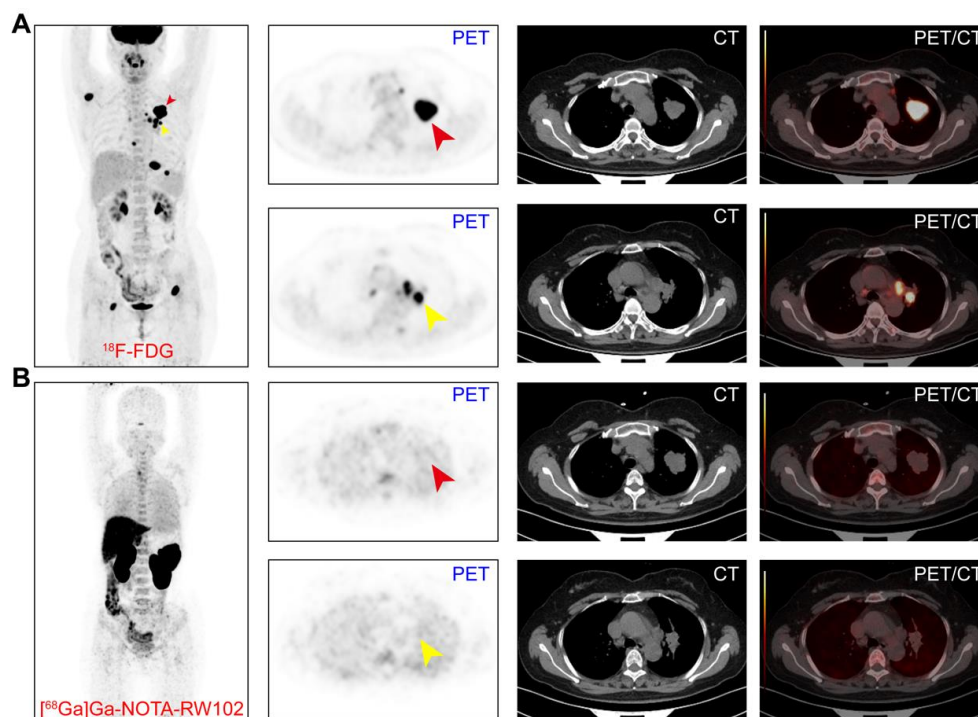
^{18}F -FDG and ^{68}Ga]-Ga-NOTA-RW102 immunoPET imaging of a patient with 2% PD-L1 expression. (A) ^{18}F -FDG images of the patient showing the primary tumor and multiple metastases across the body (The red arrow shows the left upper lobe lesion, and the yellow arrow shows the left hilar lymph node metastases; from left to right: MIP image, PET images, CT images, and PET/CT fused images). (B) ^{68}Ga]-Ga-NOTA-RW102 PET/CT images of the patient (The red arrow shows the left upper lobe lesion and the yellow arrow shows the left hilar lymph node metastasis; from left to right, MIP image, PET images, CT images, and PET/CT fused images).
